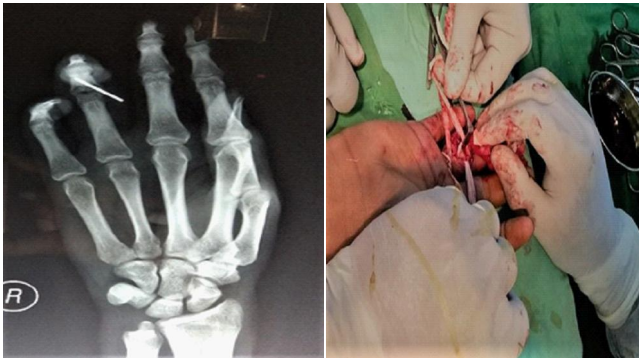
10 showing immediate post op x-ray&Intra op photos of Volar plate arthroplasty
